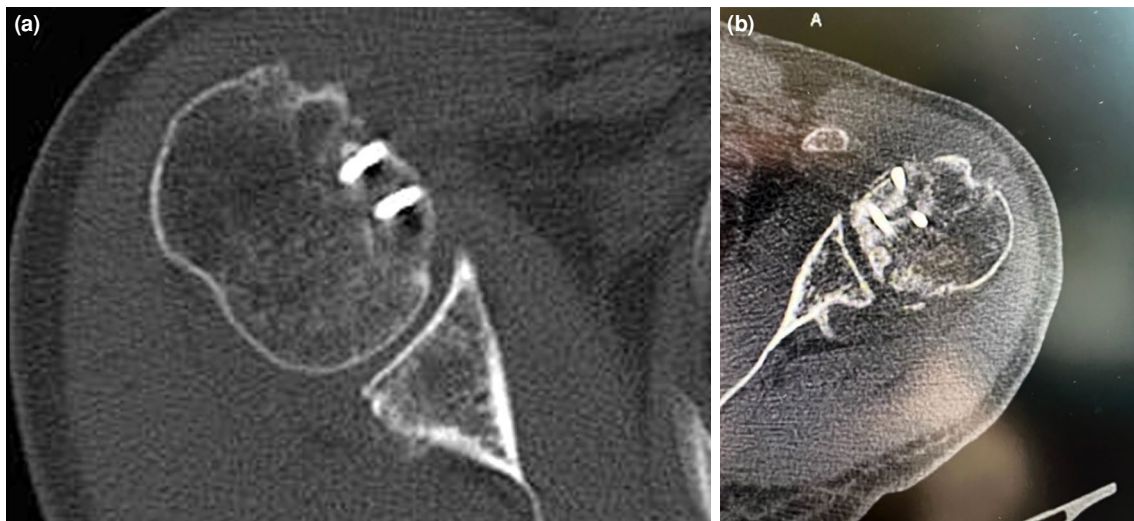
Postoperative computed tomography scan (axial views) showing that the reverse Hill-Sachs lesion has completely filled and disappeared. (a) Right, (b) Left.
